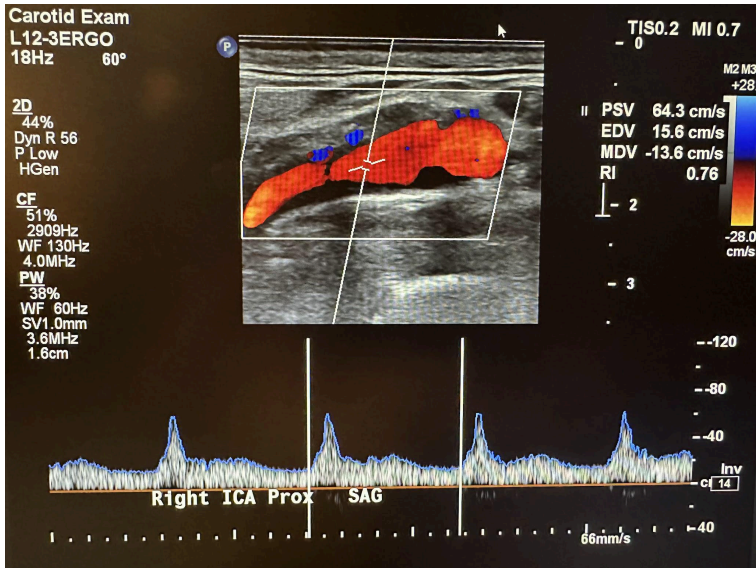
Ultrasound image showing the thermal index and mechanical index of a carotid exam in the top right corner.
